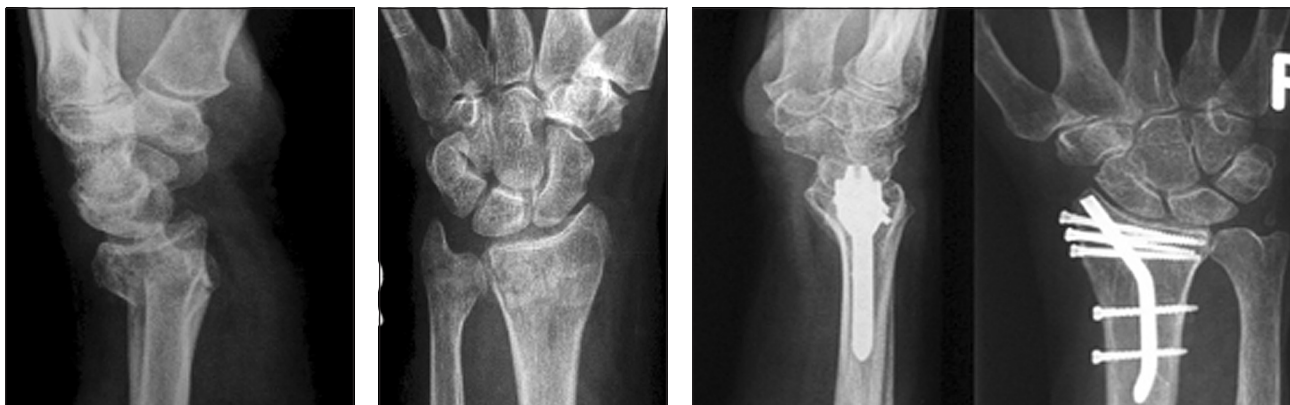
X-ray evaluation
